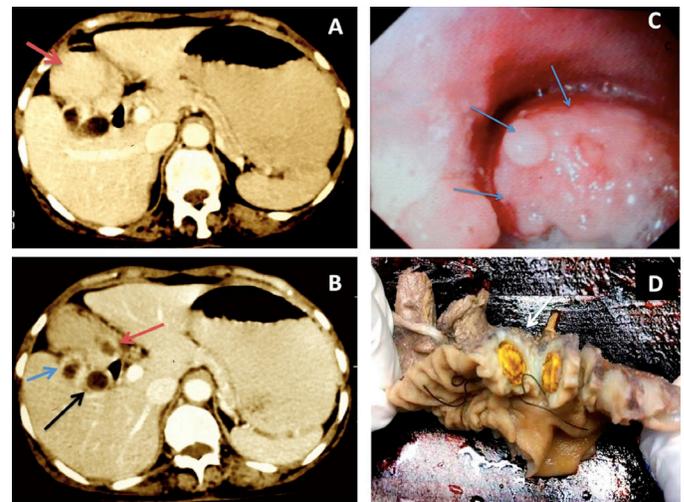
Computed tomography of abdomen showing (A): distended stomach and proximal duodenum (arrow), (B): An irregular thickening seen in the proximal duodenum (red arrow) along with thick-walled gallbladder (blue arrow) and a large gallstone (black arrow), (C): Upper gastrointestinal endoscopy showing growth in the proximal duodenum (arrows), (D) Gross pathological examination showing intramural gallstone in the duodenum (arrow).
